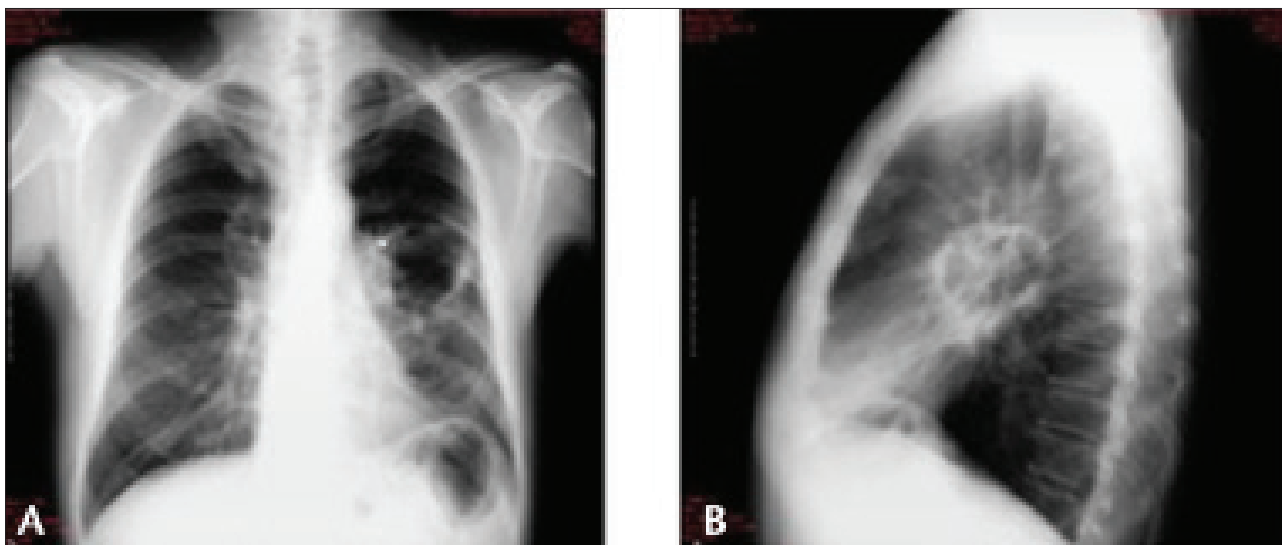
Posterior-anterior and lateral chest radiograph.
